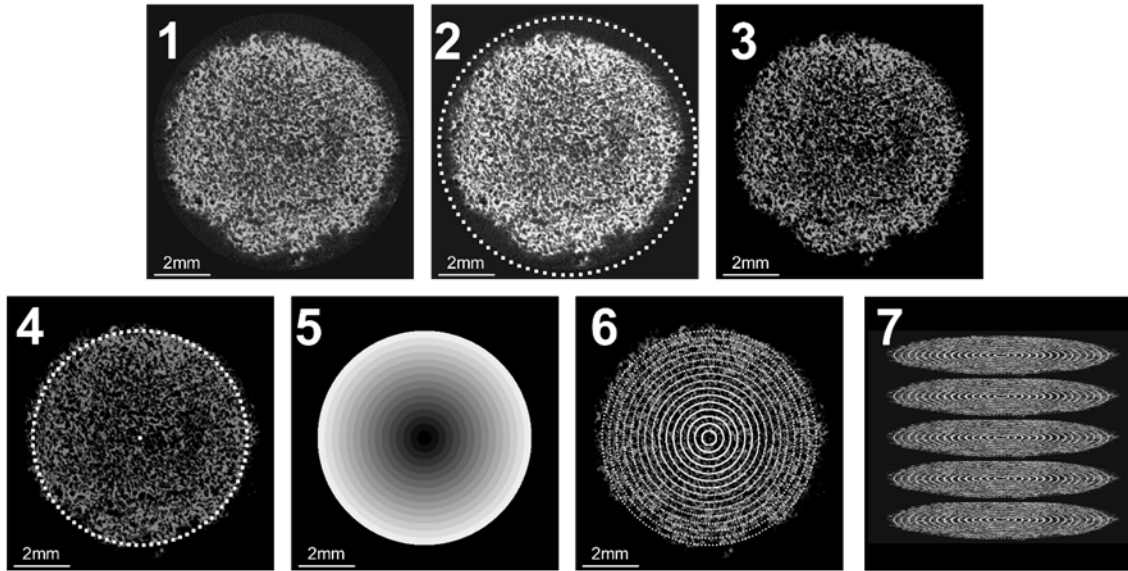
Procedure of micro-computed tomographic analysis of mineral deposition.
